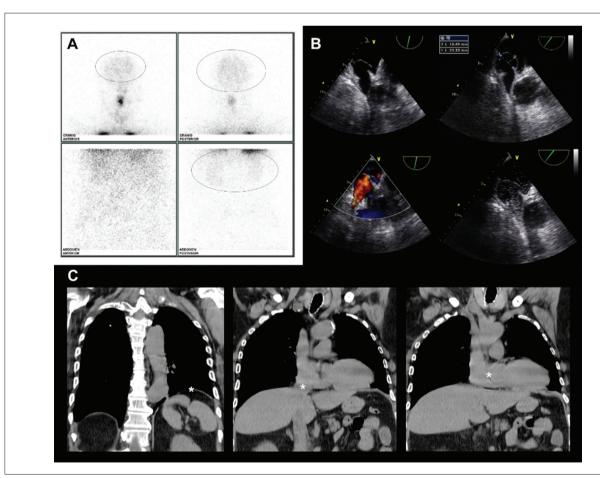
Panel A: V/Q scan demonstrating brain and kidney uptake of 99mTc-macroaggregated albumin; Panel B: TOE demonstrating PFO and interatrial septal aneurysm, with a large resting R-L shunt visible by color Doppler and agitated saline injection; Panel C: CT imaging demonstrating left hemidiaphragm elevation*, changing the supra-hepatic inferior vena cava axis* and the heart position* horizontally.
